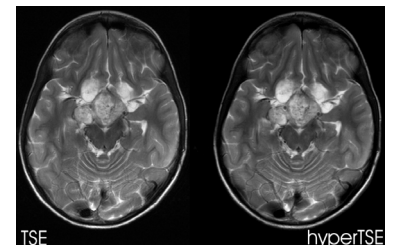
Comparison of a TSE and hyperTSE image at 3T from a patient with a pilocytic astrocytoma (clinical routine MRI). An intrinsic T2 weighted contrast correction with the validated EPG concept was employed. Both display the same contrast and resolution.
